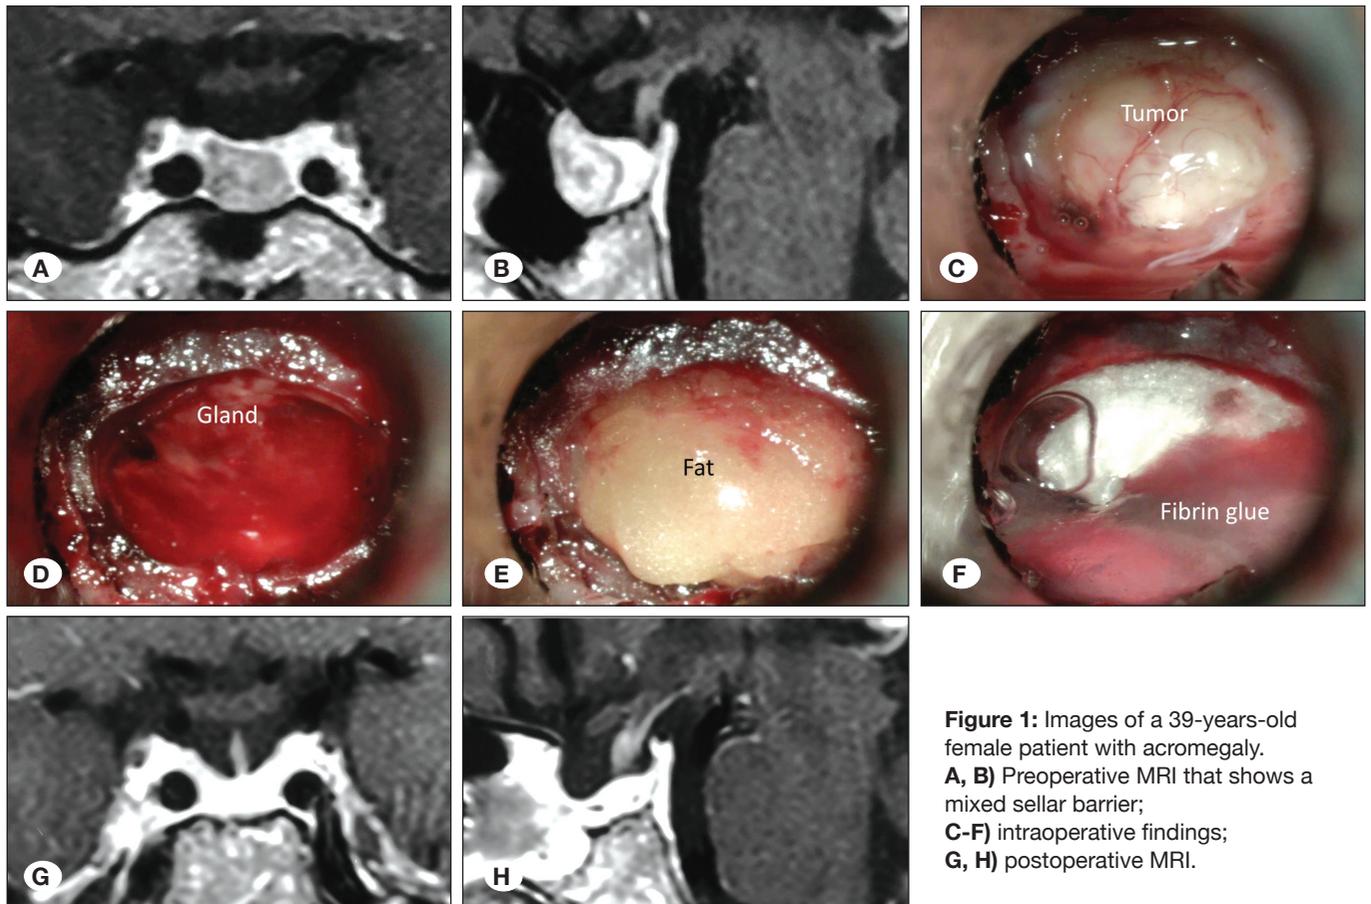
Images of a 39-years-old female patient with acromegaly. A, B) Preoperative MRI that shows a mixed sellar barrier; C-F) intraoperative findings; G, H) postoperative MRI.
